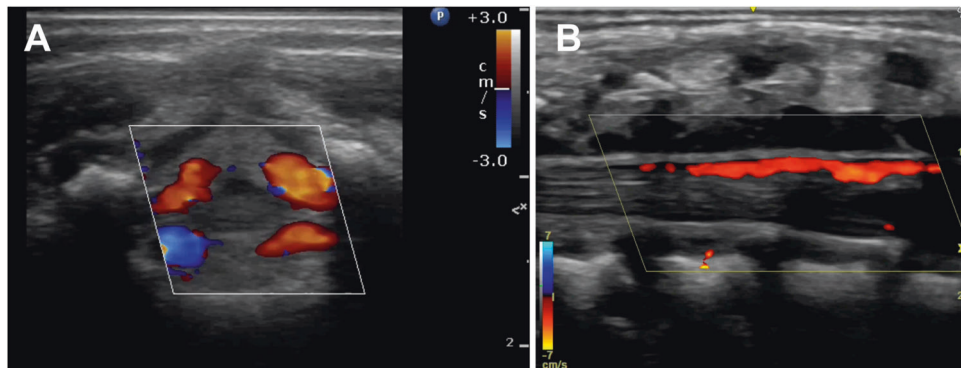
Doppler ultrasound imaging of blood vessels in the region of the lumbar spine. Transverse (A) and sagittal (B) views showing flow in blood vessels at the level of the conus medullaris and cauda equina.
